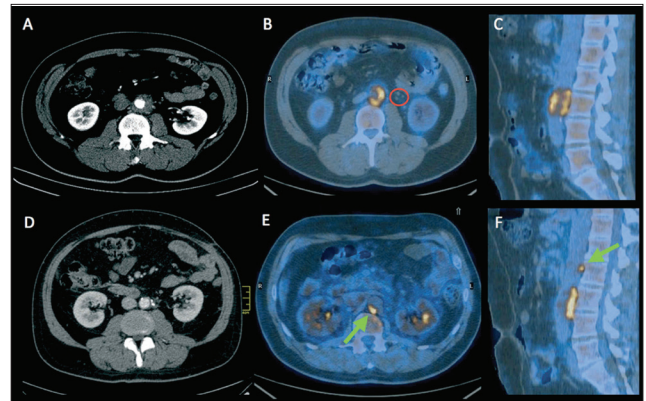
(A) Transaxial CE-CT image performed at diagnosis, showing periaortic solid tissue and locoregional lymph nodes. (B) Transaxial and (C) Sagittal ¹⁸F-FDG-PET/CT fused image performed at diagnosis, showing ¹⁸F-FDG uptake in the periaortic tissue; no ¹⁸F-FDG uptake in lymph nodes reported at CE-CT (red circle). (D) Transaxial CE-CT image performed during corticosteroid therapy, showing size reduction of the solid tissue. (E) Transaxial and (F) sagittal ¹⁸F-FDG-PET/CT fused image performed one month after the end of therapy, showing.
